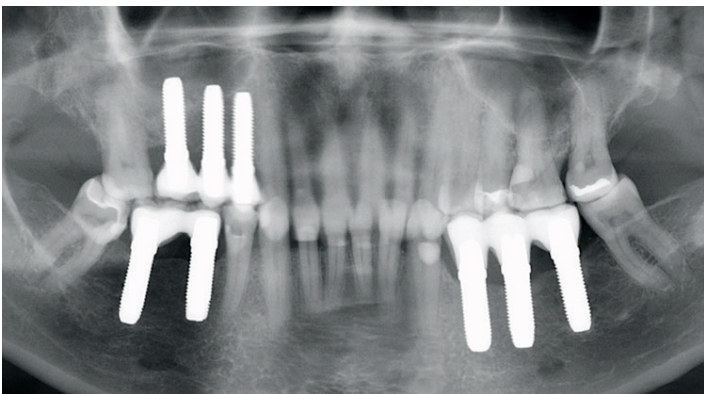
OPG x-ray taken in March 2019 showing the absence of bone loss around the eight implants.
